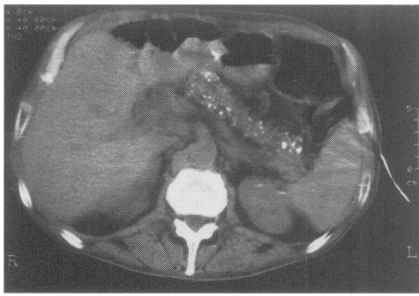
CT scan of the pancreas with diffuse calcification in the gland. At operation, biopsy confirmed locally advanced adenocarcinoma in the neck and body
